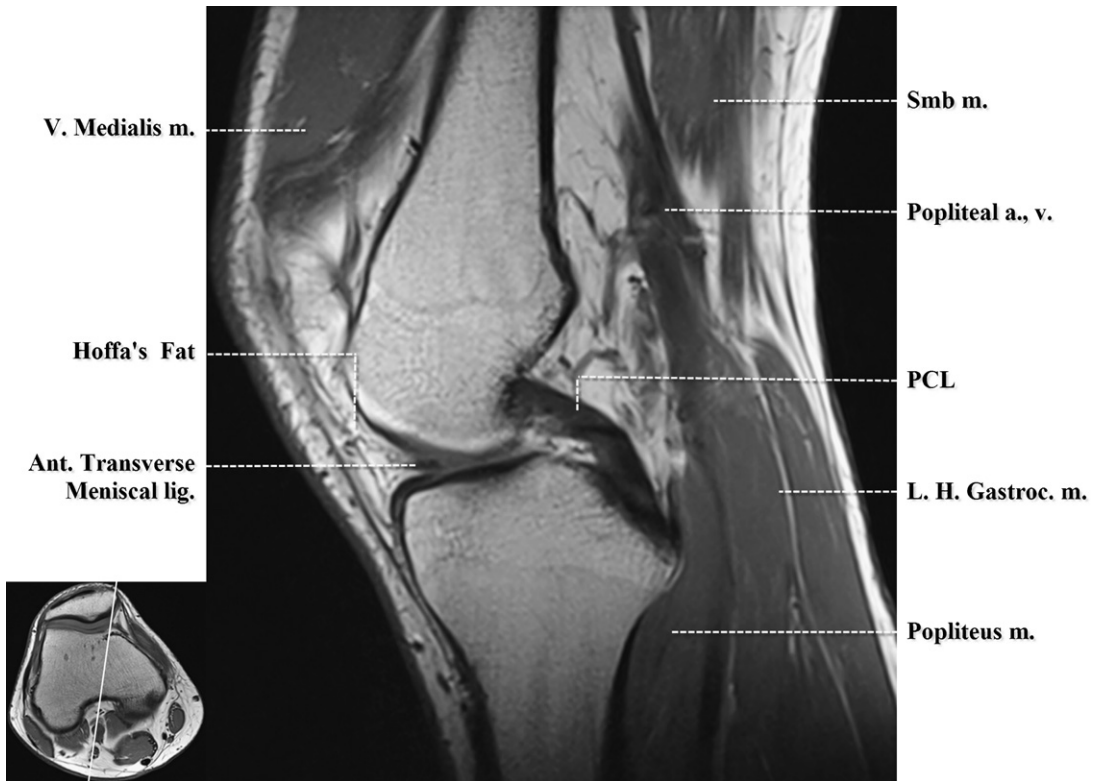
Sagittal T1-weighted image. Intercondylar notch. a., artery; Ant., anterior; m., muscle; L.H. Gastroc., lateral head gastrocnemius; lig., ligament; PCL, posterior cruciate ligament; Smb, semimembranosus; V., vastus; v., vein.
